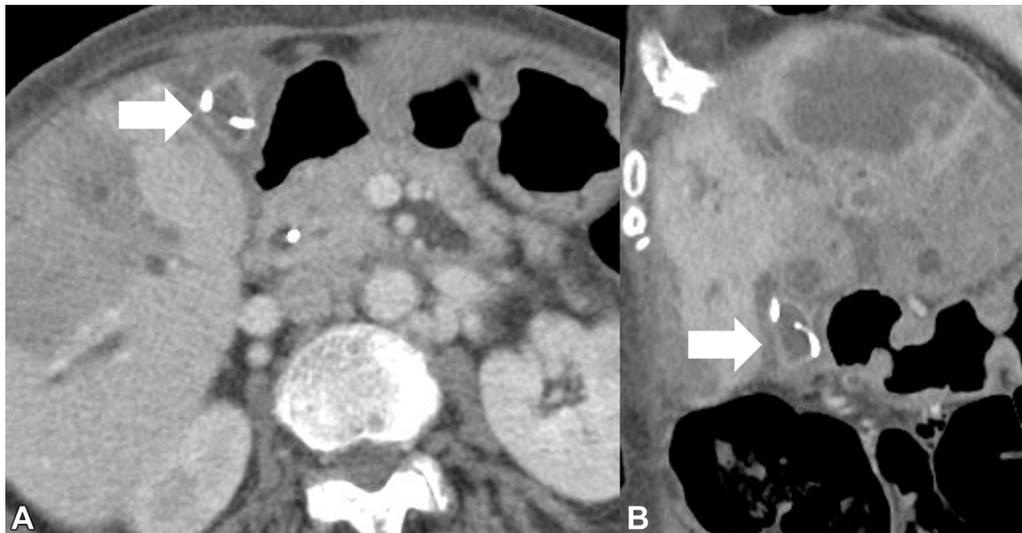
CT showed improvement of acute cholecystitis after endoscopic transpapillary gallbladder stent placement (*arrow*).
